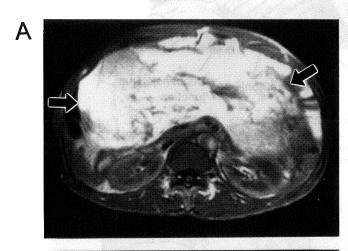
Abdominal unenhanced CT scan shows huge fatty mass (arrows).
